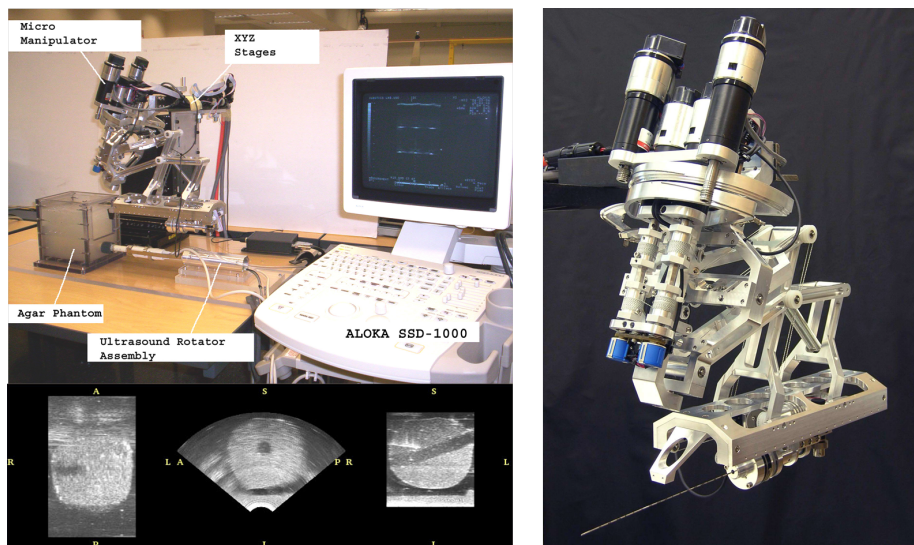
A robotic manipulator for 3D Ultrasound Guided Percutaneous Needle Insertion [1010].
